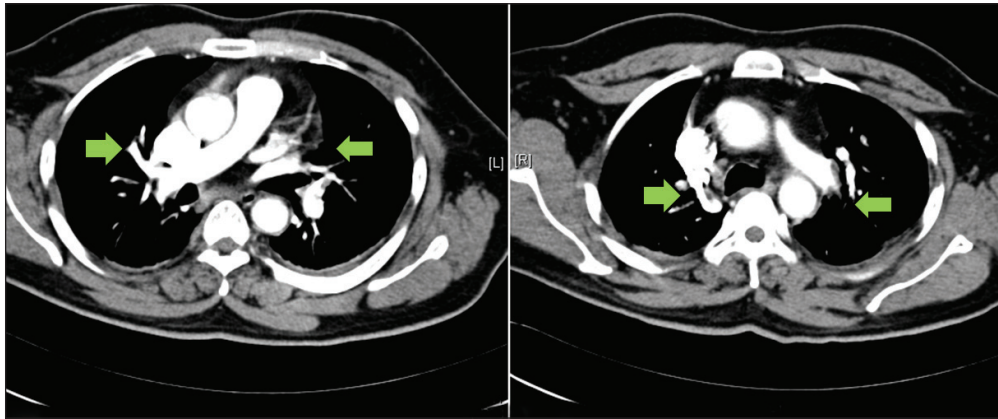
CT pulmonary angiography images show multiple small bilateral pulmonary emboli (arrows).
